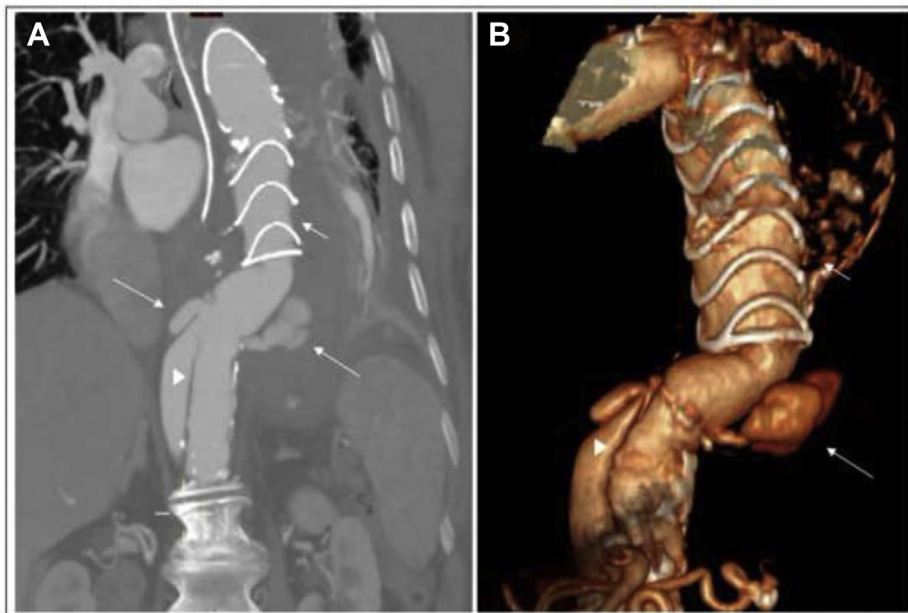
Rupture of para-anastomotic aneurysm. Computed tomography angiogram (CTA), coronal view (A) and three-dimensional reconstruction (B), demonstrating the frozen elephant trunk (*short arrow*), Dacron graft and contrast extravasation surrounding the distal anastomosis of the graft (*long arrow*), and the remaining aortic dissection (*arrowhead*).
